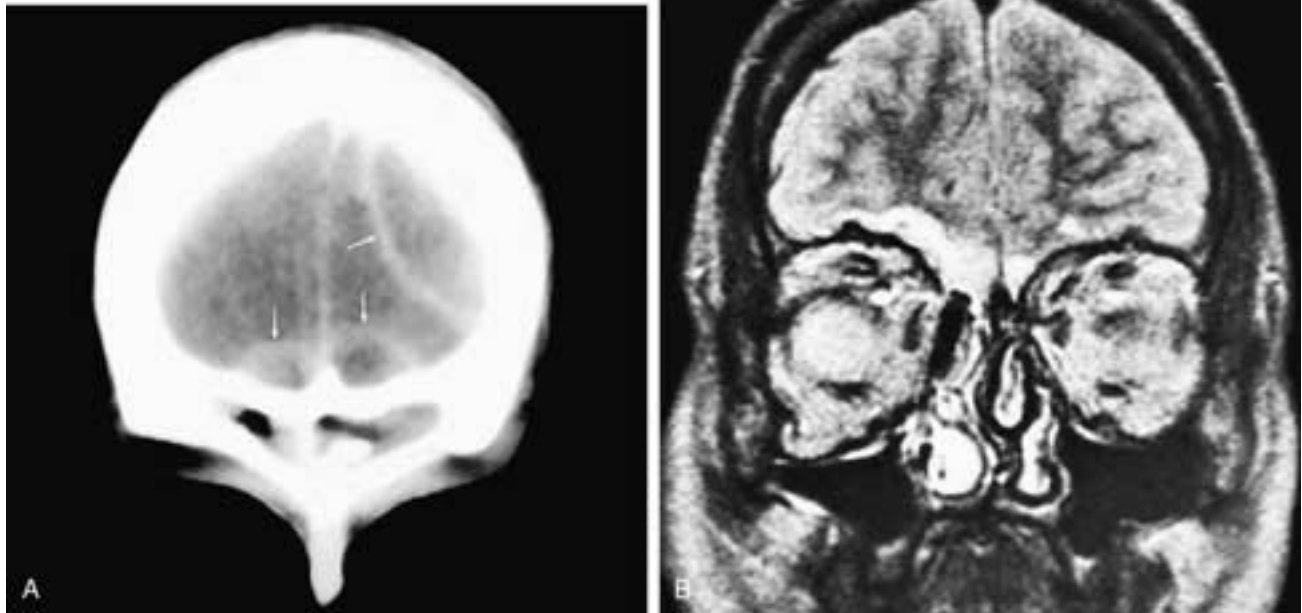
In A, a coronal CT scan, there is an osteoma obstructing the left frontal sinus and three epidural abscesses (*arrows*) that occurred within 48 hours of the initial frontal sinus symptoms. In B, a coronal T2-weighted MR image, there is an area of high signal intensity above the right orbit and in the base of the midline anterior cranial fossa. This patient had cerebritis secondary to frontal sinusitis.
